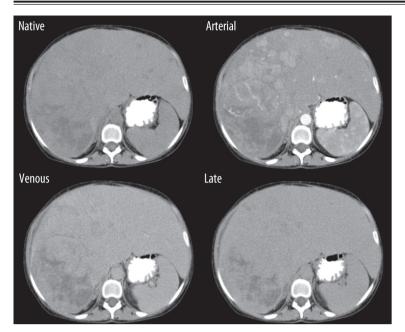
Patient E-J, CT performed in February 2006, axial slices before and after contrast media administration: in arterial, venous and late phases — progression of tumor in the right liver lobe, numerous smaller foci.
